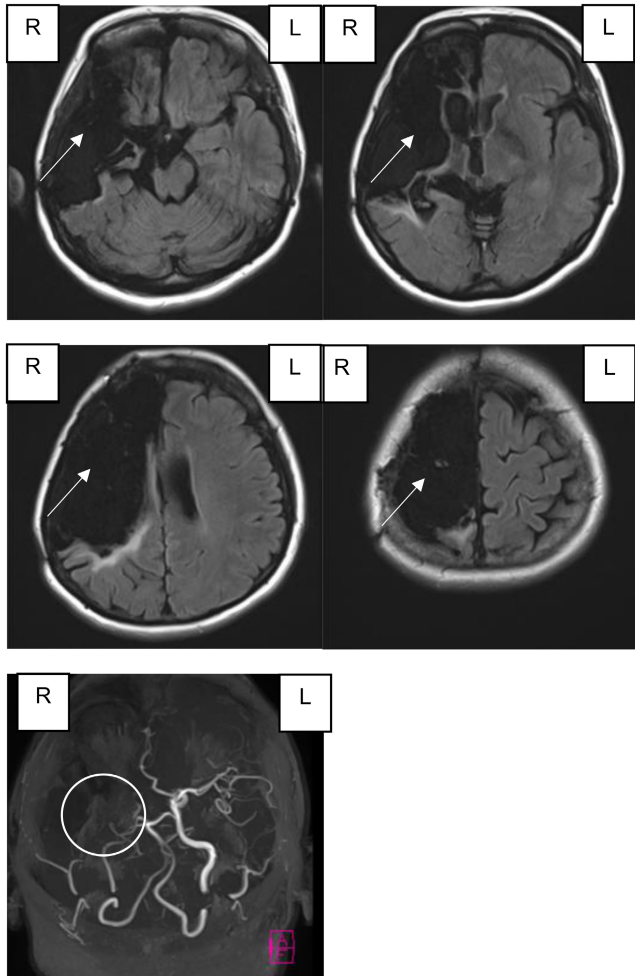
Brain magnetic resonance imaging for Case 2 upon admission to the convalescent rehabilitation ward. Diffusion-weighted images show extensive areas of high signal intensity in the right anterior and middle cerebral artery regions (arrowheads). Magnetic resonance angiography showing an occluded right internal carotid artery (circle).
